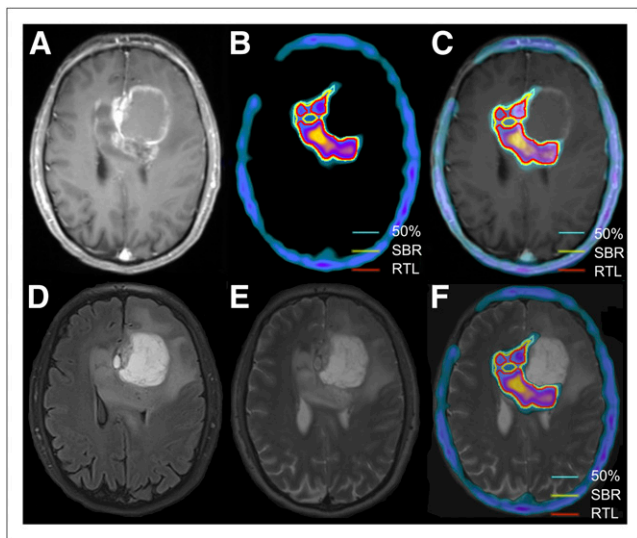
(A) T1-weighted MR image after contrast, showing left frontal ring-enhanced glioblastoma tumor with infiltration via corpus callosum to right side. (B) ^{18}F -FLT PET image with different segmented PVs. (C) Fused ^{18}F -FLT PET and T1-weighted MR image after contrast. (D) Fluid-attenuated inversion recovery MR image. (E) T2-weighted MR image. (F) Fused ^{18}F -FLT PET and T2-weighted MR image, showing most active localization of tumor in infiltrative part. 50% = PV of tumor based on 50% isocontour of SUV_{max} .
